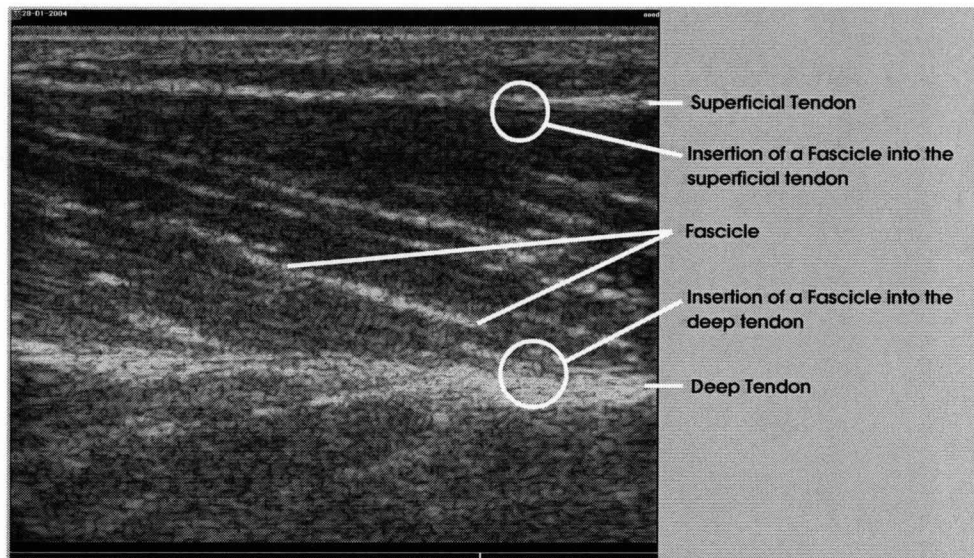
The cross-section developed by the ultrasound computer.
